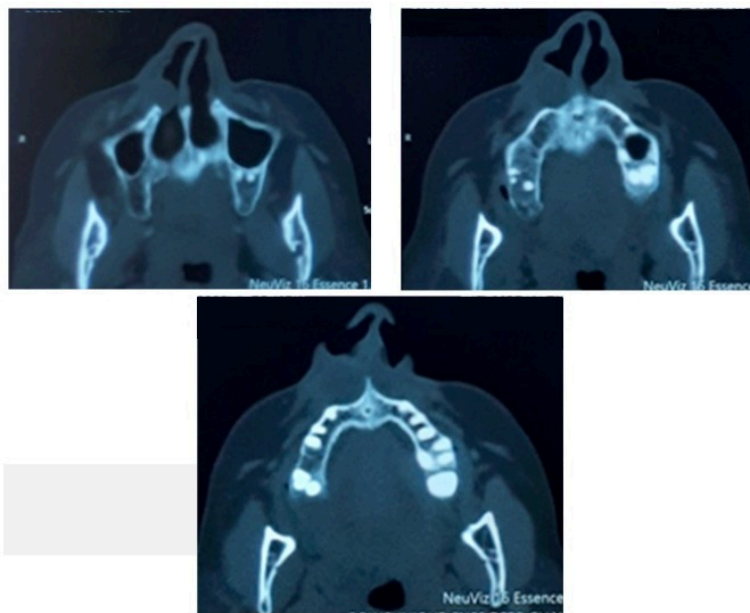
Axial Computed tomography: a well-defined oval mass in the right nasal region, without any bone destruction.
